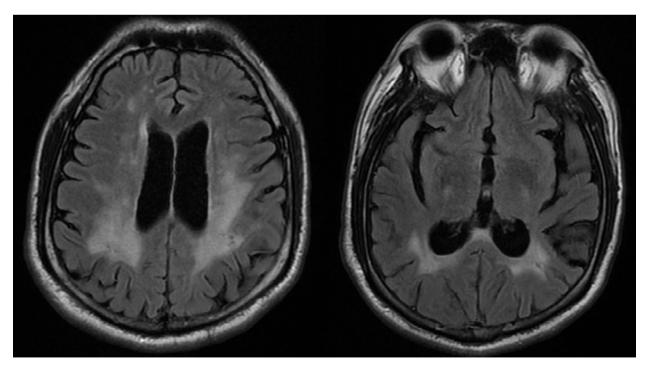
Brain magnetic resonance imaging five months later with findings suggesting chronic hypertensive encephalopathy with a resolving acute hypertensive encephalopathy episode
